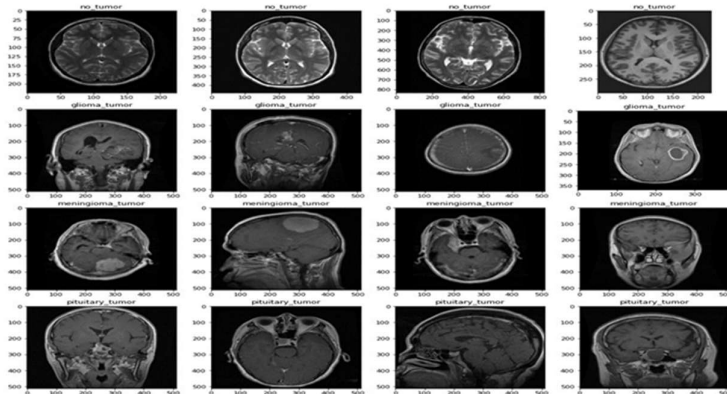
MRI Images of Brain Tumor.
